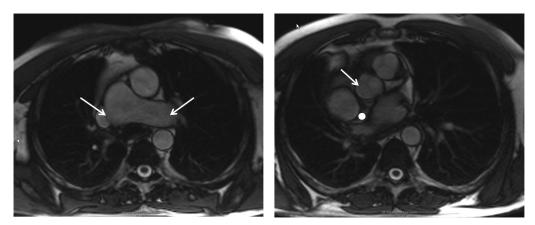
Cardiac magnetic resonance image showing the relationship between high atrial septum from right and left atria and pulmonary cusps. Left: L-transposition of great vessels with pulmonary artery (identified by right and left pulmonary branch, white arrows) located posteriorly to the aorta. Right: Relation of pulmonary cusps (white arrow) and interatrial septum (para-Hisian area, white spot).
